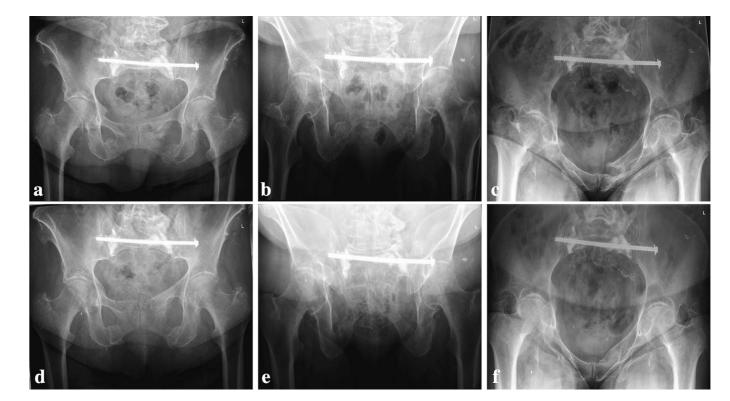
Follow-up x-ray studies in (a/d) plain anteroposterior, (b/e) outlet, (c/f) inlet projection at six weeks and 18 months postoperatively. The transsacral screw remained stable over time and did not break or become loose. No further fracture progression occurred during follow-up.
